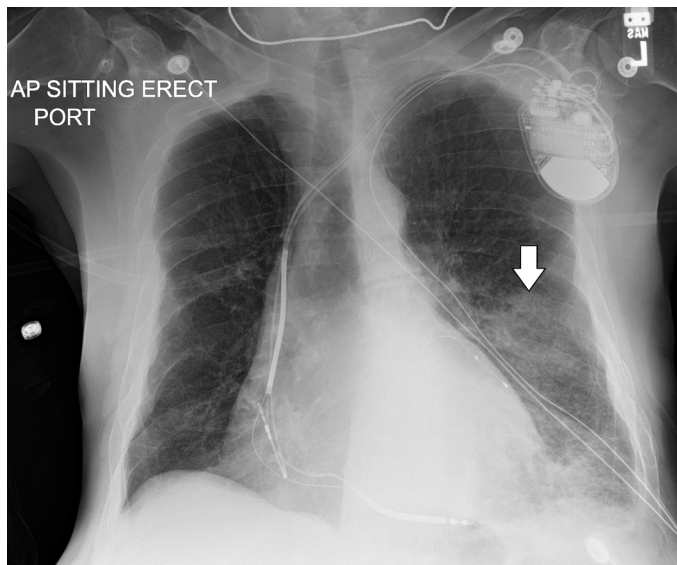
The initial anterior-posterior chest radiograph demonstrating a left lower lobe infiltrate (arrow).
